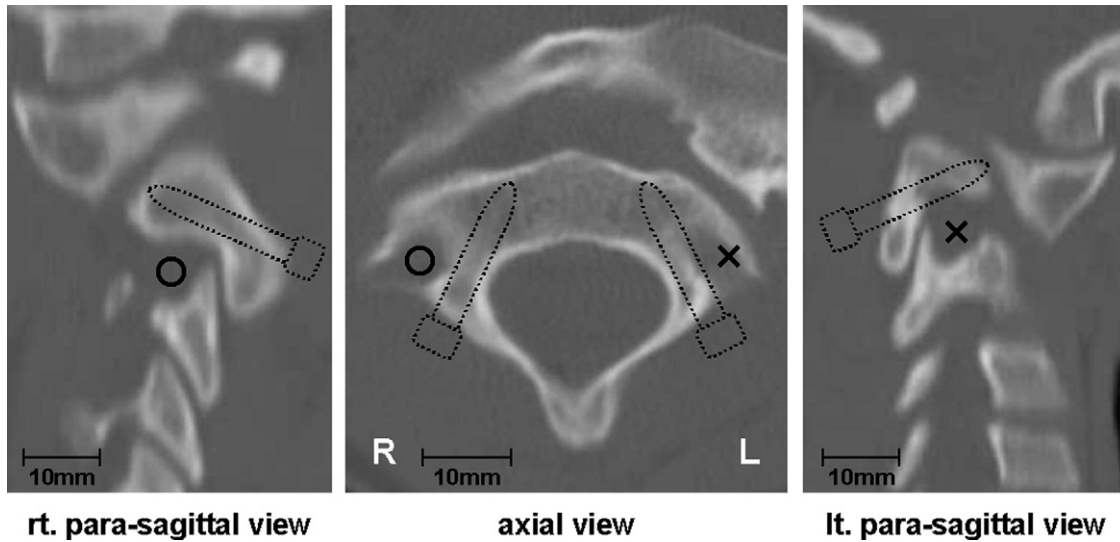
Morphologic analysis of C2 pedicles by CT imaging in case 2. Insertion of pedicle screws was judged dangerous on the left side by CT imaging. (lt, left; rt, right.)
